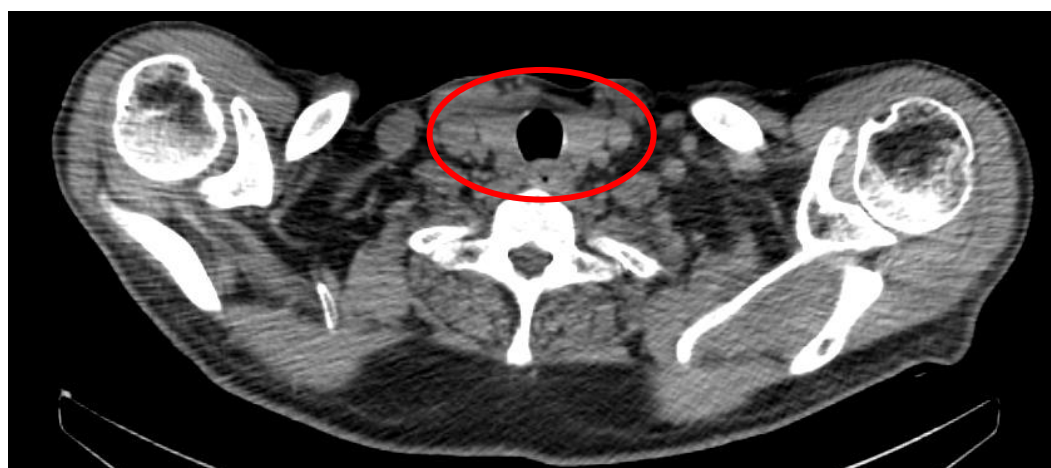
The effect of beam hardening caused by the shoulder bones and clavicaulae on the thyroid tissue on CT.
